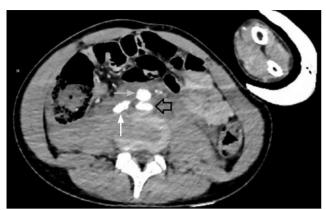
A computed tomography angiography image showing bleeding restricted to retroperitoneum. Black arrow indicates bleeding limited to retroperitoneum. Grey arrow indicates abdominal aorta and white arrow indicates inferior vena cava.
